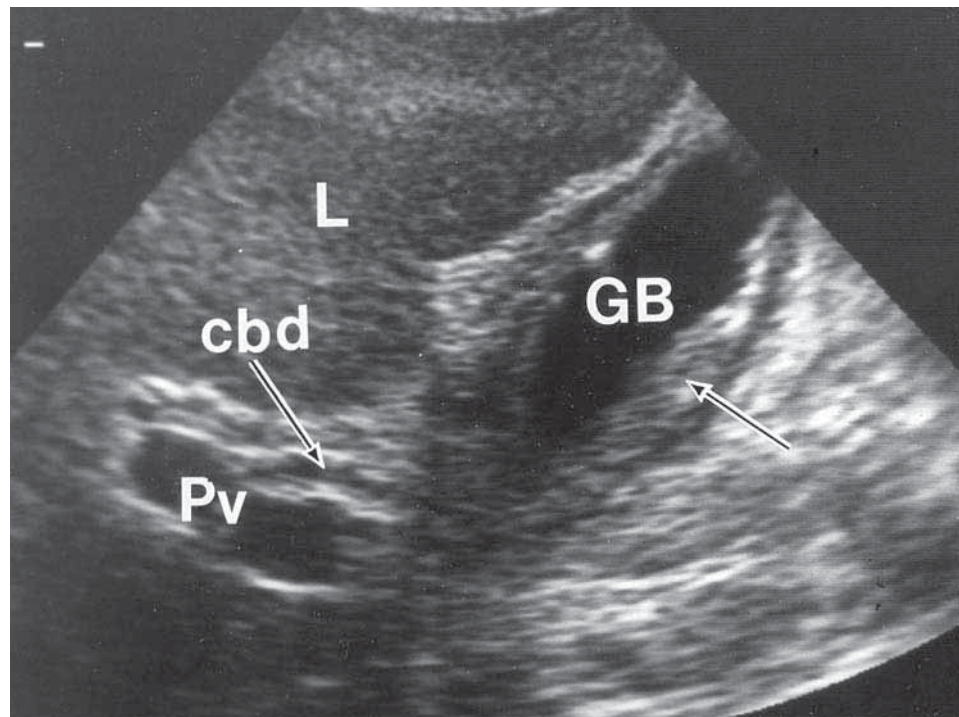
Parasagittal Ultrasound of Abdomen Showing Inflammation of the Gallbladder
